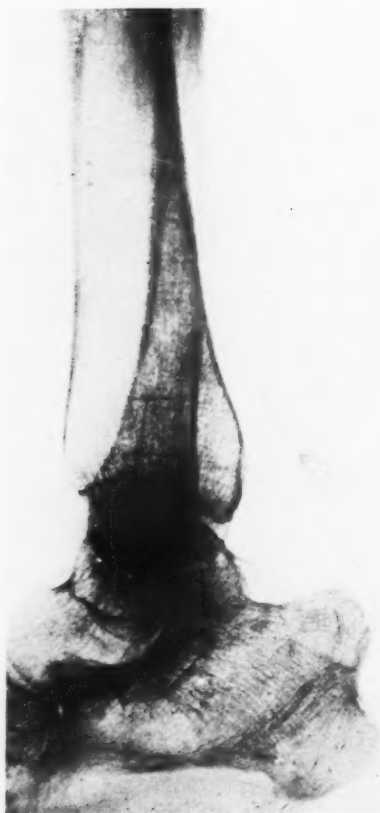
Roentgenogram showing an exostosis of the os calcis. There is a rather large calcified area in the tendo achillis just above its insertion. Two bony growths are present, similar in shape and location to those shown in Figure 2.
